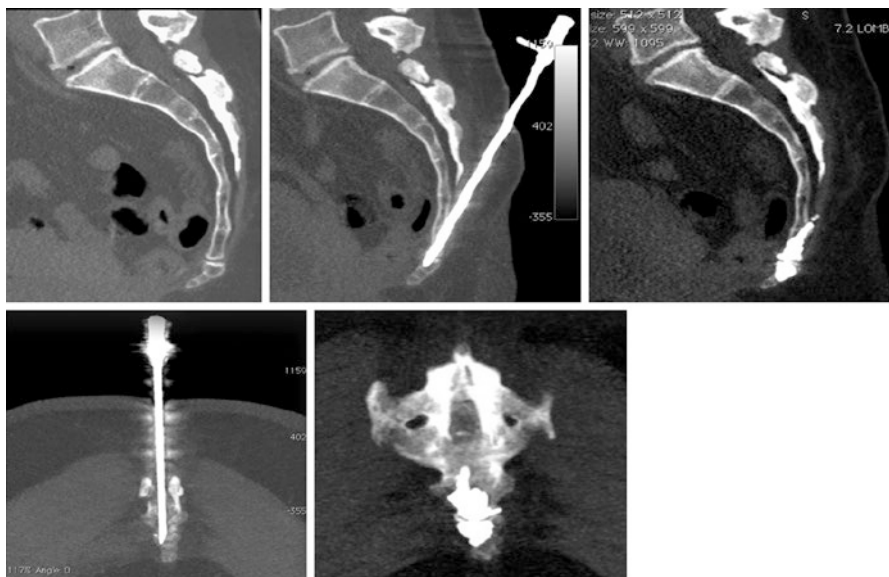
Coccygeal subluxation in a 34-year-old woman. On sagittal 2D CT scan (*top left*), detachment of the coccyx from the sacrum is appreciated. To perform coccygeoplasty, a 13G Jamshidi needle has been introduced through the S4–S5 body directly into the coccyx (*top middle, left down*), and 2–3 cc of PMMA has been injected, re-attaching the coccyx to the sacrum (*top right and down right images*)
